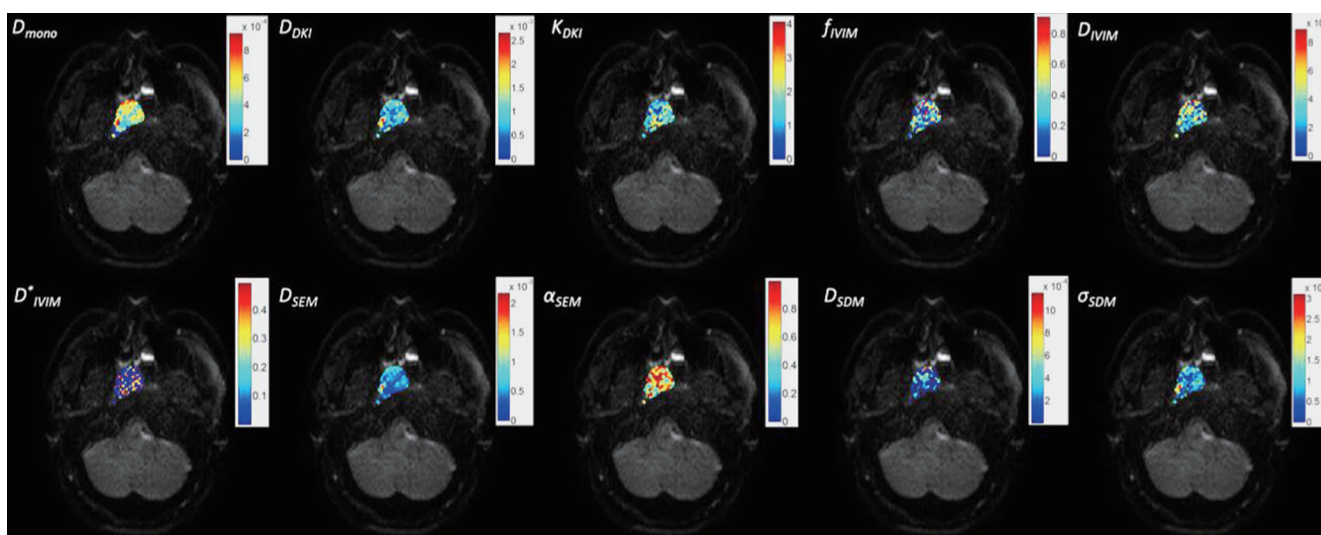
Maps of the mono-exponential apparent diffusion coefficient (ADC) and non-Gaussian diffusion parameters (goodness of fit $R^2 > 0.8$) for a primary NPC tumor overlaid on the diffusion-weighted imaging (DWI) image with $b=0$. Reprinted with permission from Yuan J, *et al. PLoS One* 2014;9:e87024.
